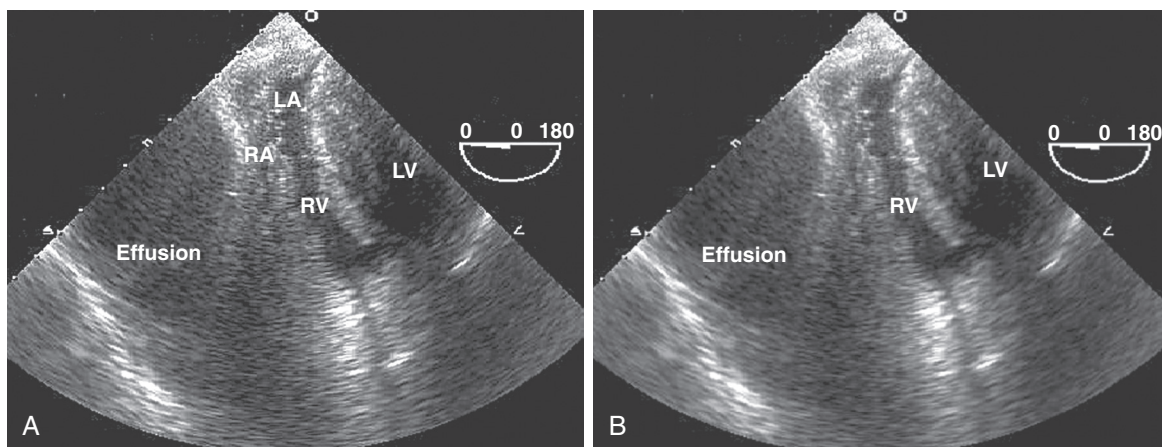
■ Cardiac tamponade. Transesophageal four-chamber view (A) shows the presence of a large effusion that severely compresses the right atrium (RA) and right ventricle (RV), which appear slitlike. The left ventricle (LV) also is small because of indirect compression and underfilling. Transgastric short-axis view (B) of the same patient shows the large pericardial effusion and severely compressed ventricular chambers. This postcardiotomy patient was in profound shock and was brought back to the operating room emergently for reexploration and drainage of the effusion. LA, left atrium.
